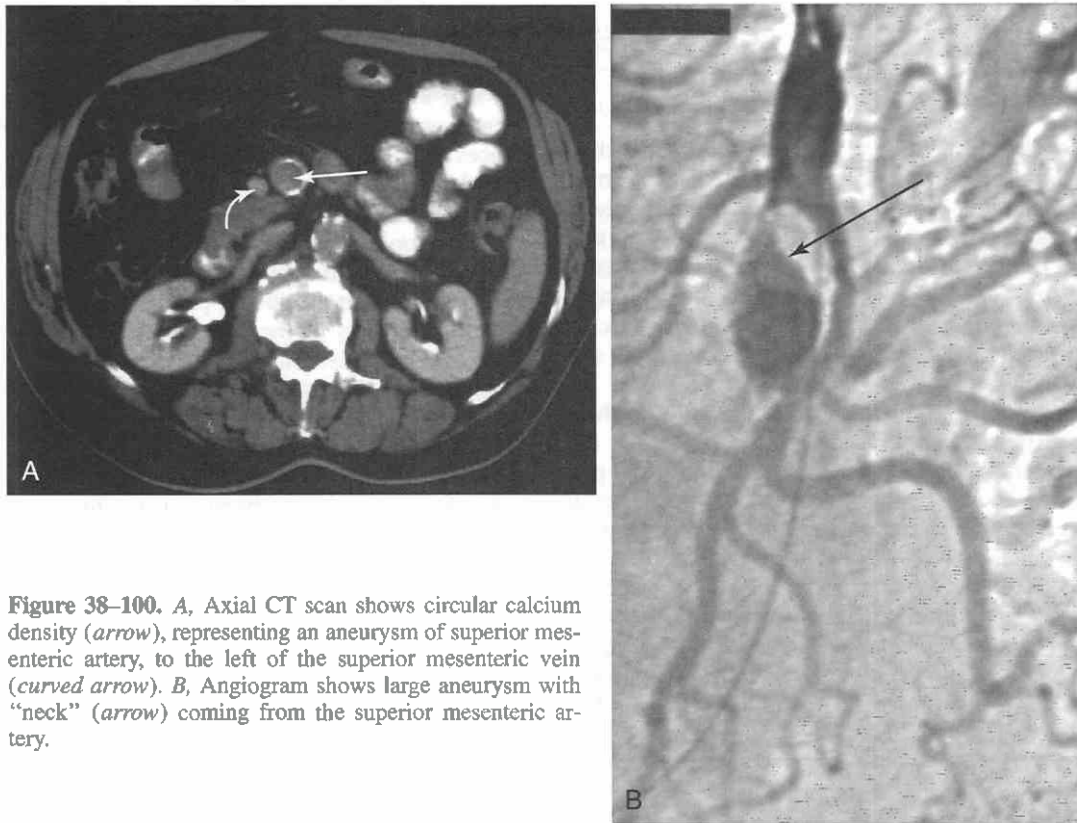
A, Axial CT scan shows circular calcium density (*arrow*), representing an aneurysm of superior mesenteric artery, to the left of the superior mesenteric vein (*curved arrow*). B, Angiogram shows large aneurysm with "neck" (*arrow*) coming from the superior mesenteric artery.
